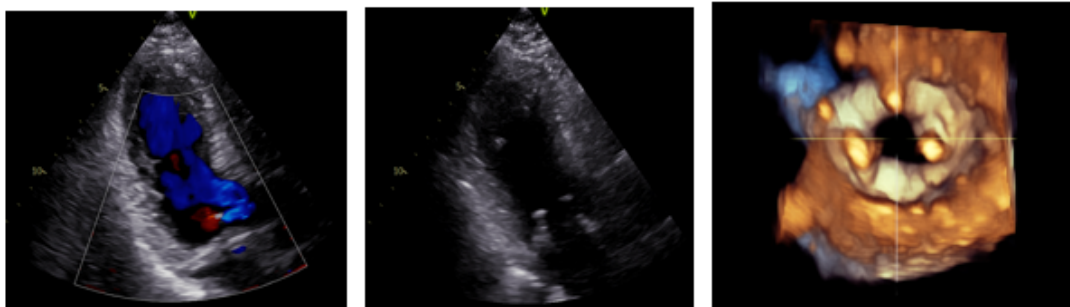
Transthoracic echocardiography showing the biological mitral valve prosthesis in the Follow up control, 24 months after surgery.
